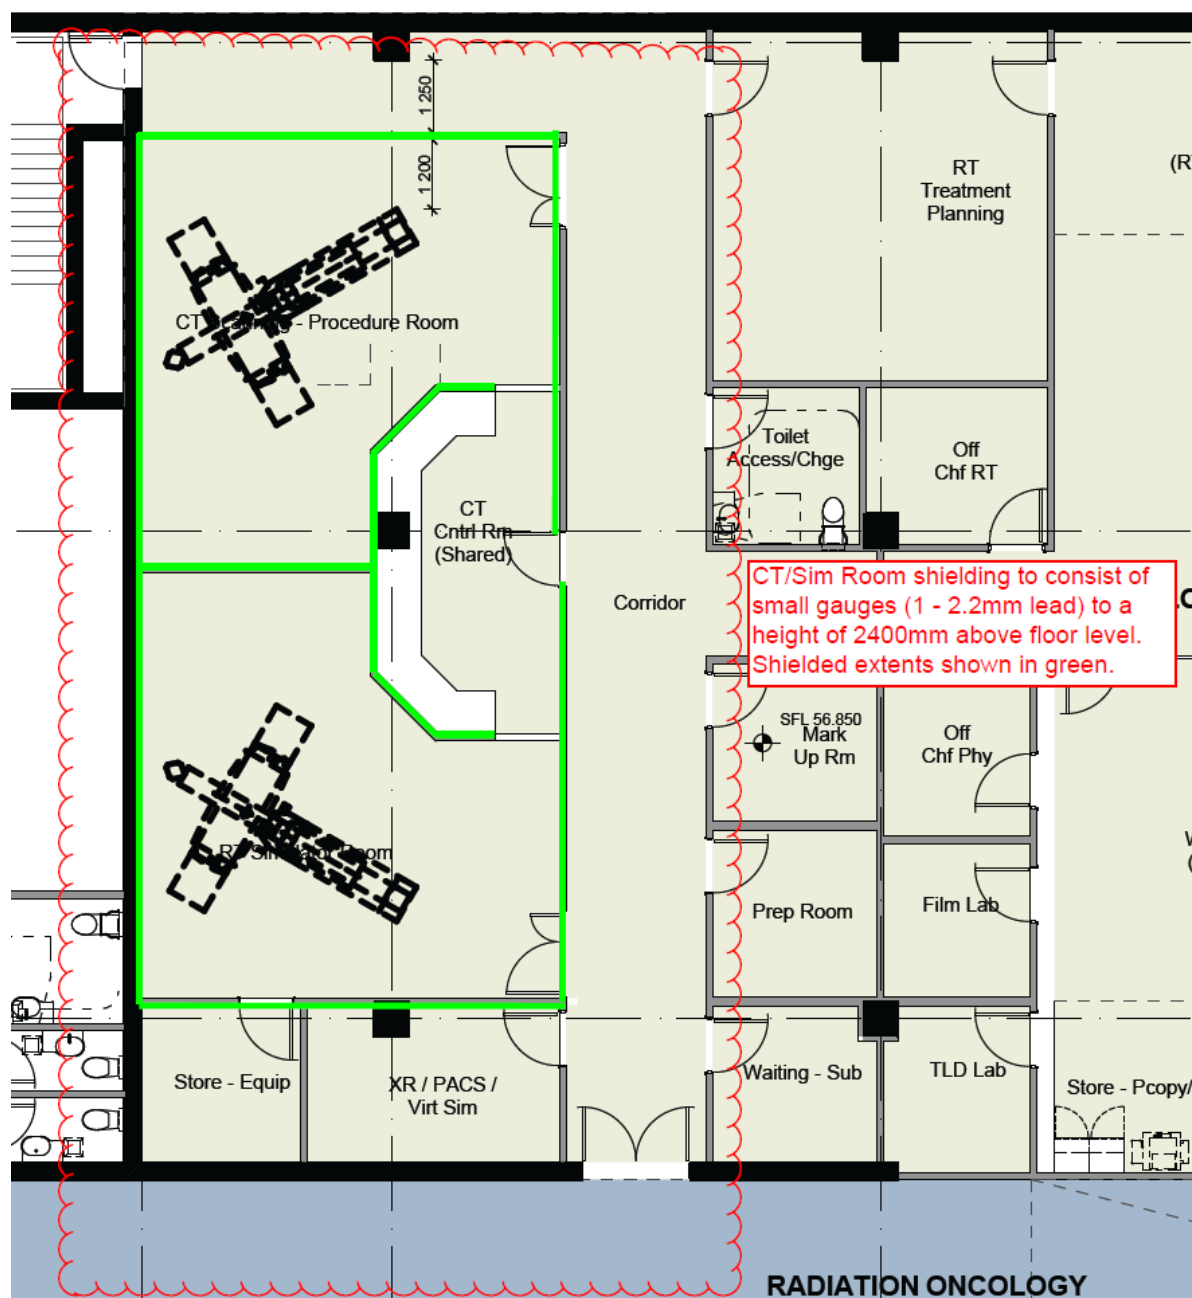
Shielding Extents for CT/Sim Suite
